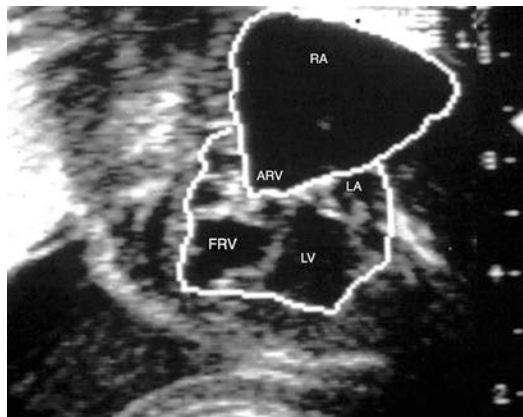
This frame is from a fetus with Ebstein's malformation where the right atrium (RA) and atrialized right ventricle (ARV) are planimetry separately from the left atrium (LA), left ventricle (LV) and the functional right ventricle (FRV). A ratio of $>1:1$ is a poor prognostic sign. Celermajer and his colleagues expanded this index. With permission from Roberson DA, Silverman NH. Ebstein's anomaly: echocardiographic and clinical features in the fetus and neonate. *J Am Coll Cardiol* 1989; 14:1300-7 © Elsevier 1989 [3]
